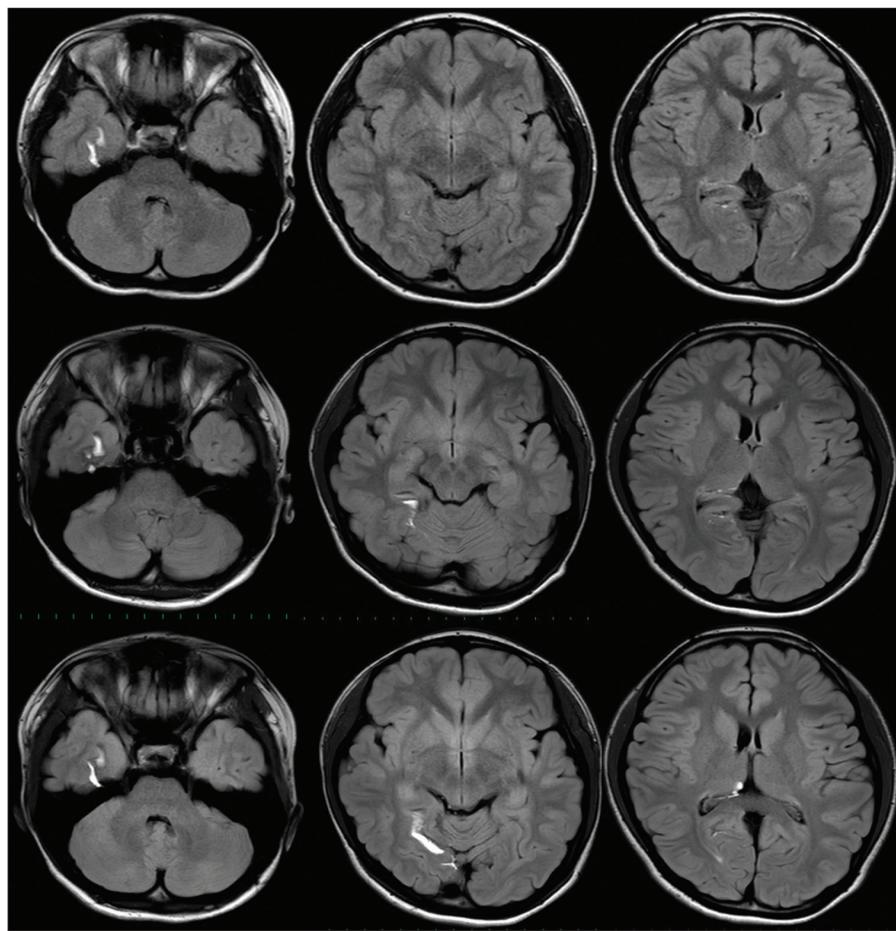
Chronological magnetic resonance imaging (MRI) changes in a patient after traumatic rupture of dermoid cyst. Upper: The initial MRI showing fat droplets in the adjacent collateral sulcus. Middle: 11 months later, MRI shows migration into the posterior part of the collateral sulcus and quadrigeminal cistern (not shown in this view). Lower: Final MRI showing the fat droplet further migrates into the third ventricle.
